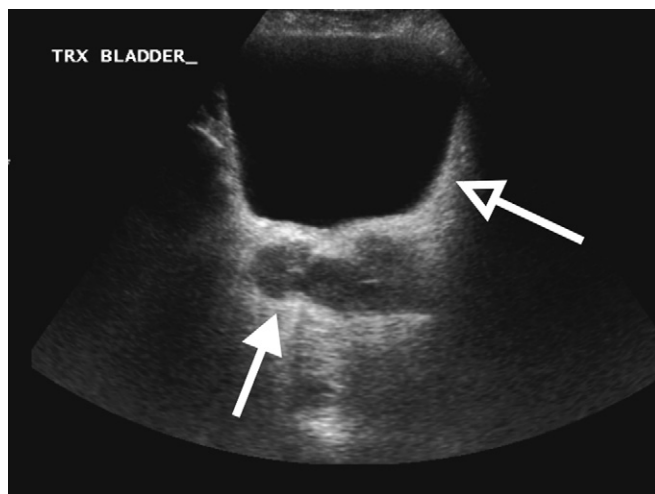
Axial, transabdominal ultrasound image through the urinary bladder identifies tubular structures that represent dilated seminal vesicles (solid arrowhead) located posterior to the bladder (open arrowhead).
